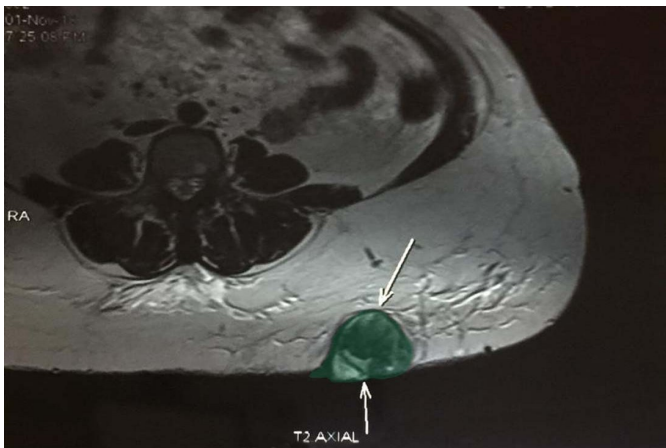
MRI OF THE GLUTEAL REGION – T2 AXIAL-SHOWING THE LESION IN THE SUBCUTANEOUS REGION. 385x278mm (72 x 72 DPI)
